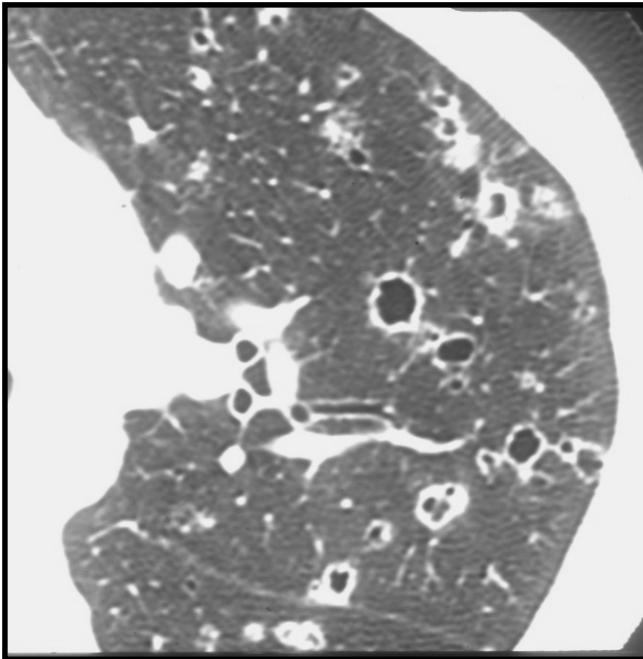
Abbott et al. Radiographics, 2004
